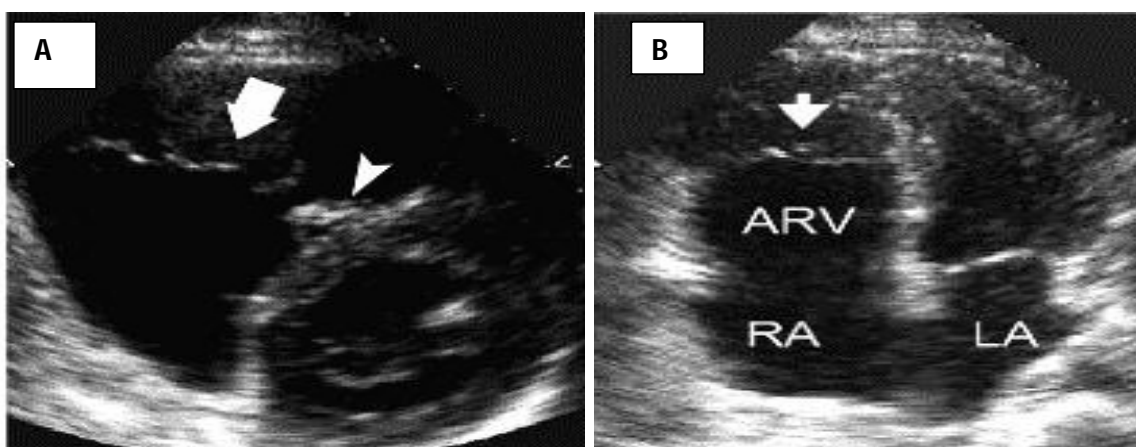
A: Echocardiogram showing elongated anterior tricuspid valve leaflet (arrow) and rudimentary septal leaflet (arrowhead). (RA= right atrium, LA= left atrium.) B: Echocardiogram showing Ebstein's anomaly (apical displacement) of the tricuspid valve (arrow) and formation of an “atrialized” right ventricle (ARV).
